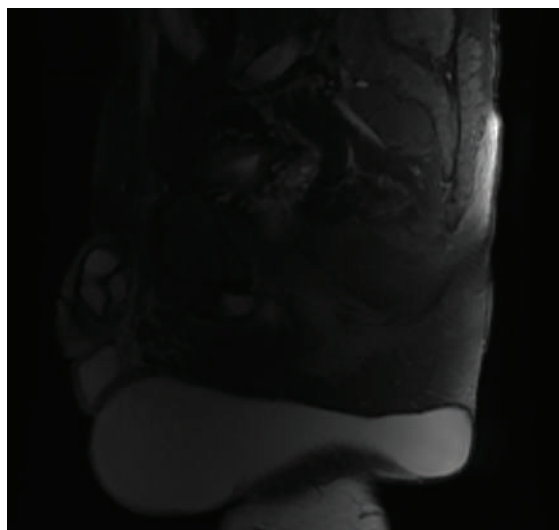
MRI image of the mass.
